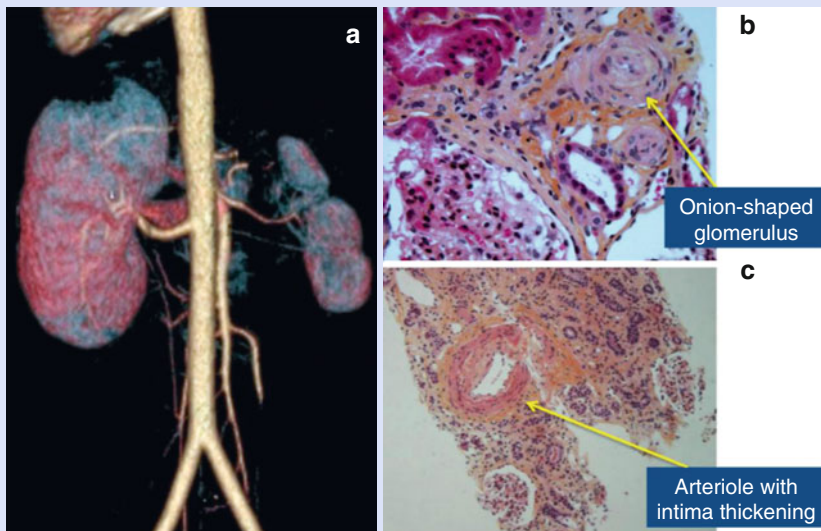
(a) CT angiogram with three-dimensional reconstruction (Courtesy Department of Medical Imaging, Montreal Children's Hospital). Atrophic right kidney. Severely scarred left kidney with prominent perfusion defect of the upper pole. (b, c) Biopsy of the left kidney (Images courtesy Department of Pathology, Montreal Children's Hospital). Severe renal glomerular and parenchymal (b) and vascular (c) injury due to severe hypertension
